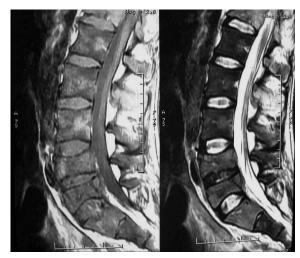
Sagittal MR images demonstrate multiple lesions with intermediate- and high signal intensty on T1-weighted images (left), high-signal intensity on T2-weighted images (right) in some lumbar vertebrae.
